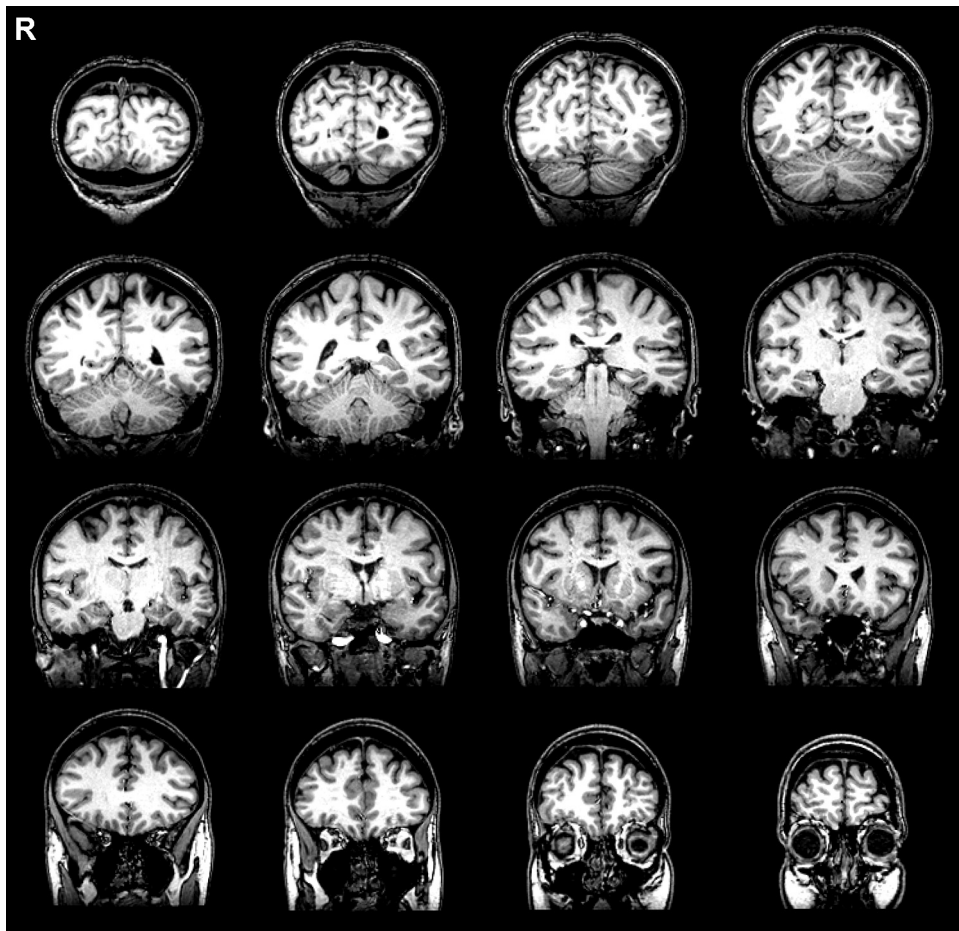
Structural imaging of AS. Coronal T1-weighted magnetic resonance images from posterior (top left) to anterior (bottom right). No structural abnormalities are apparent.
